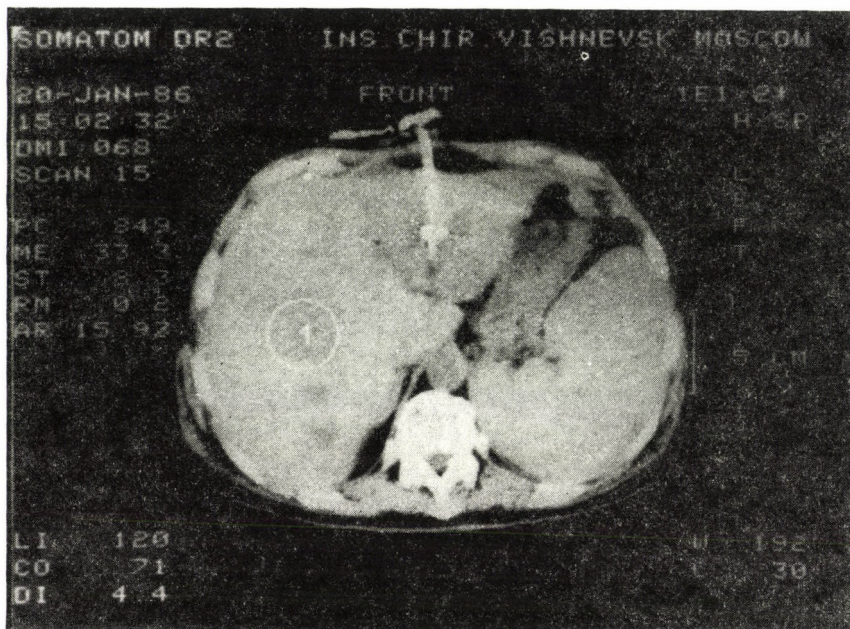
CT scan of percutaneous transhepatic drain in the projection of segment III of the liver. On the border of segments VI-VII a nondrained abscess is seen
